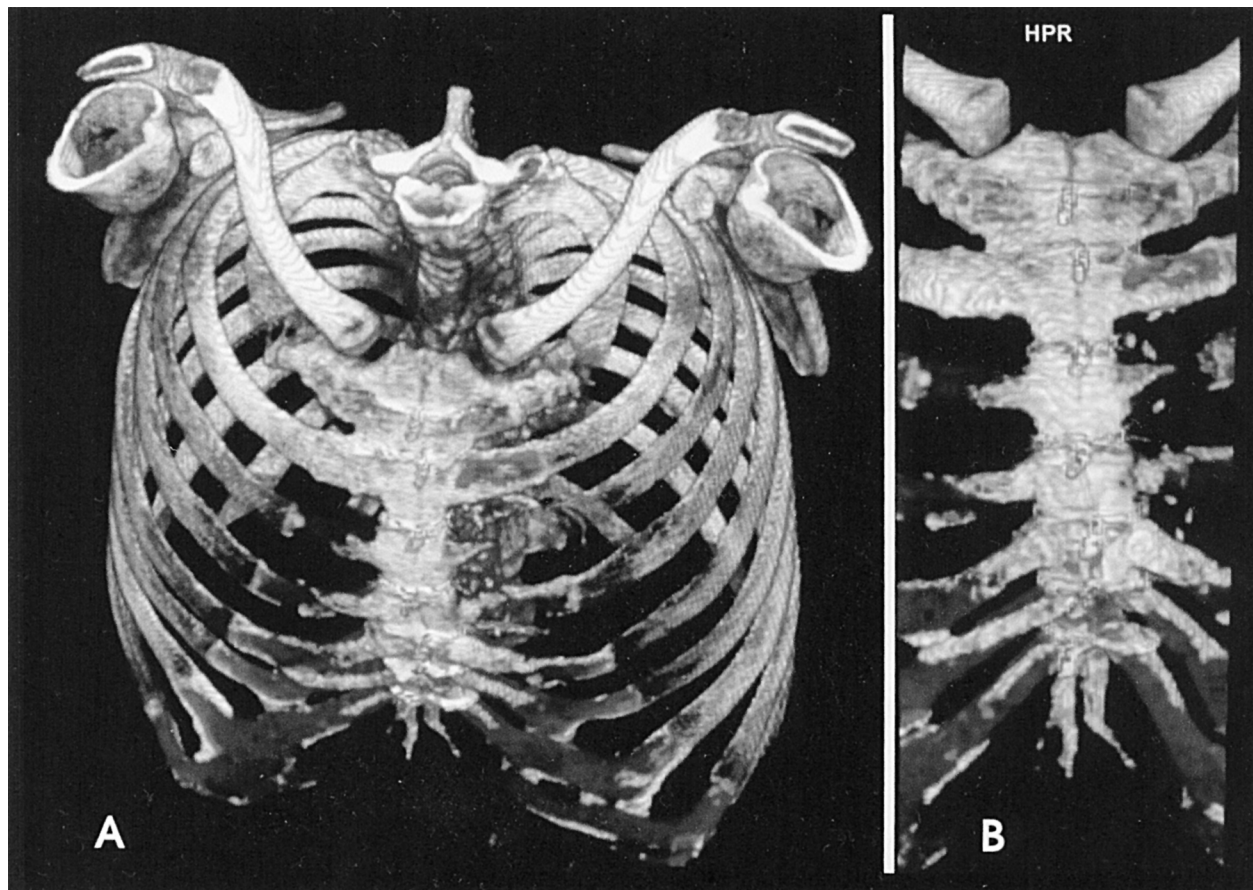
Preoperative computed tomography scans of chest with three-dimensional reconstruction. (A) Thoracic cage. (B) Selected location in sternum, showing necrotic (dark) areas.
